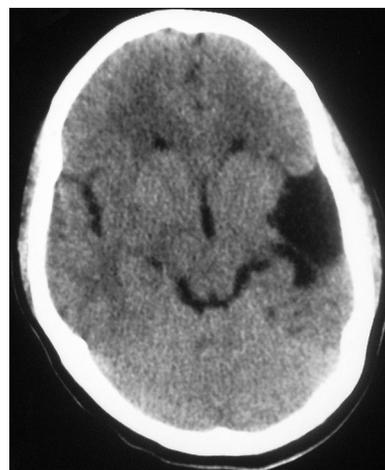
CT Brain showing encephalomalacia
